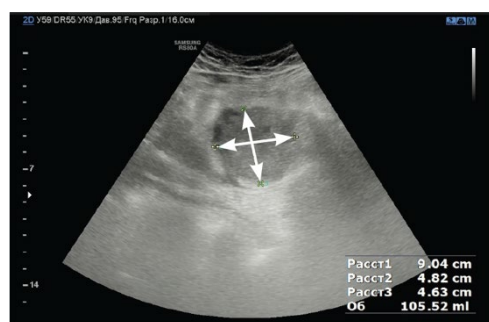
Echsonographic sign of appendicular abscess (white arrows)
